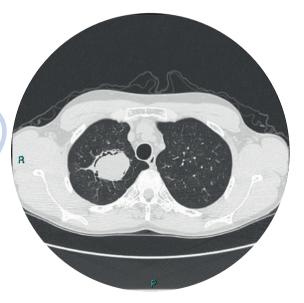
(Left) CT scan showing a transverse crosssection of the thoracic cavity of a patient with pulmonary aspergillosis. Source: Domenico Nicolettti, University of Bologna.
